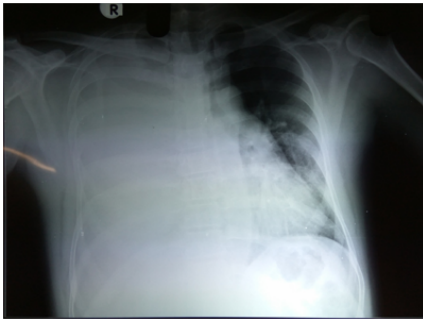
Antero-posterior chest X-ray showing opacification of the right hemithorax with widened mediastinum.
